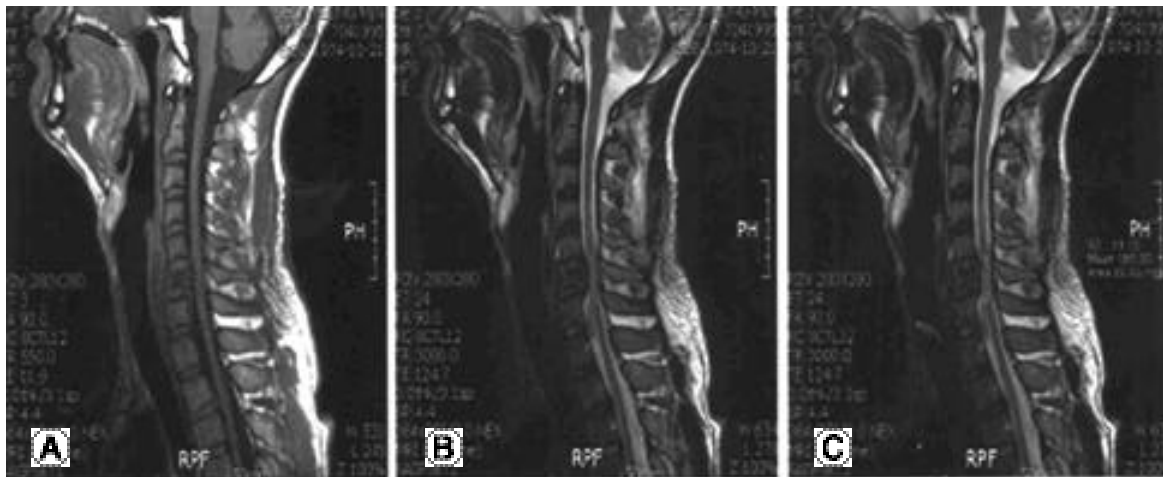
(Type II) MRI of 22-year-old male with C6 tear-drop fracture who become incomplete quadriplegia following incar-TA. Shows neurologic recovery(Frankel grade C to D).
